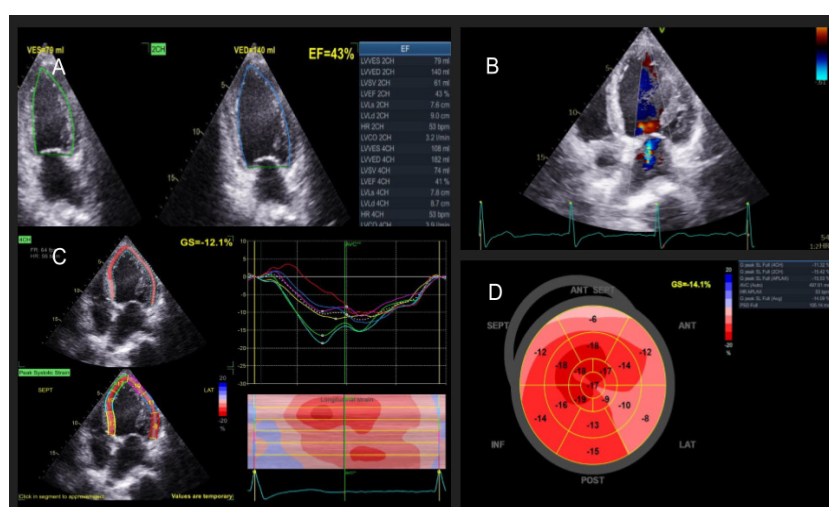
Post-catheter ablation echocardiography examination: A. LVEF assessment by Simpson biplane method showed LVEF improvement; B. Apical 4-chambers view showed LV volume reduction with MR severity reduction; C. 4-chamber LV GLS tracing showed reduced 4-ch GLS value; D. Average GLS showed improved value (-14.1 %) (LVEF: Left ventricle ejection fraction; LV: Left ventricle; MR: Mitral regurgitation; GLS: Global longitudinal strain).
